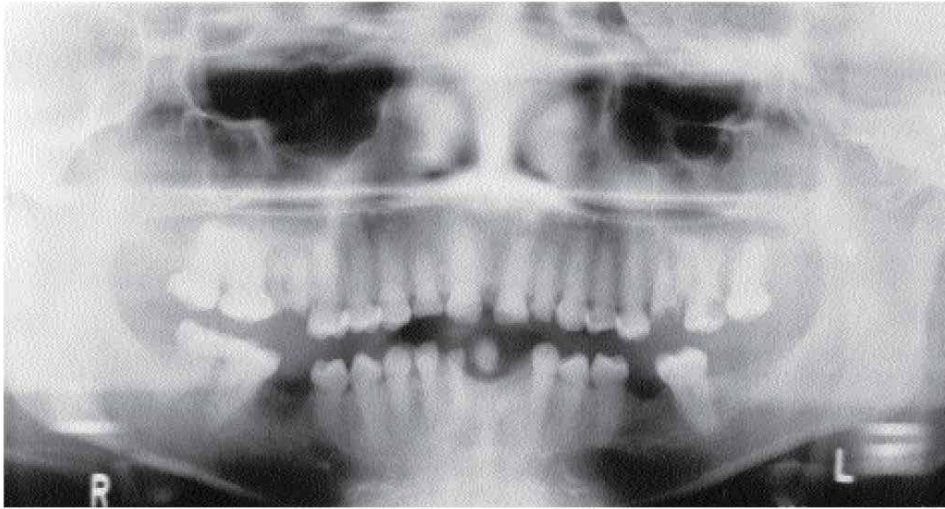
Panoramic radiograph showing complete obliteration of the pulp excepting 37 and 47.
